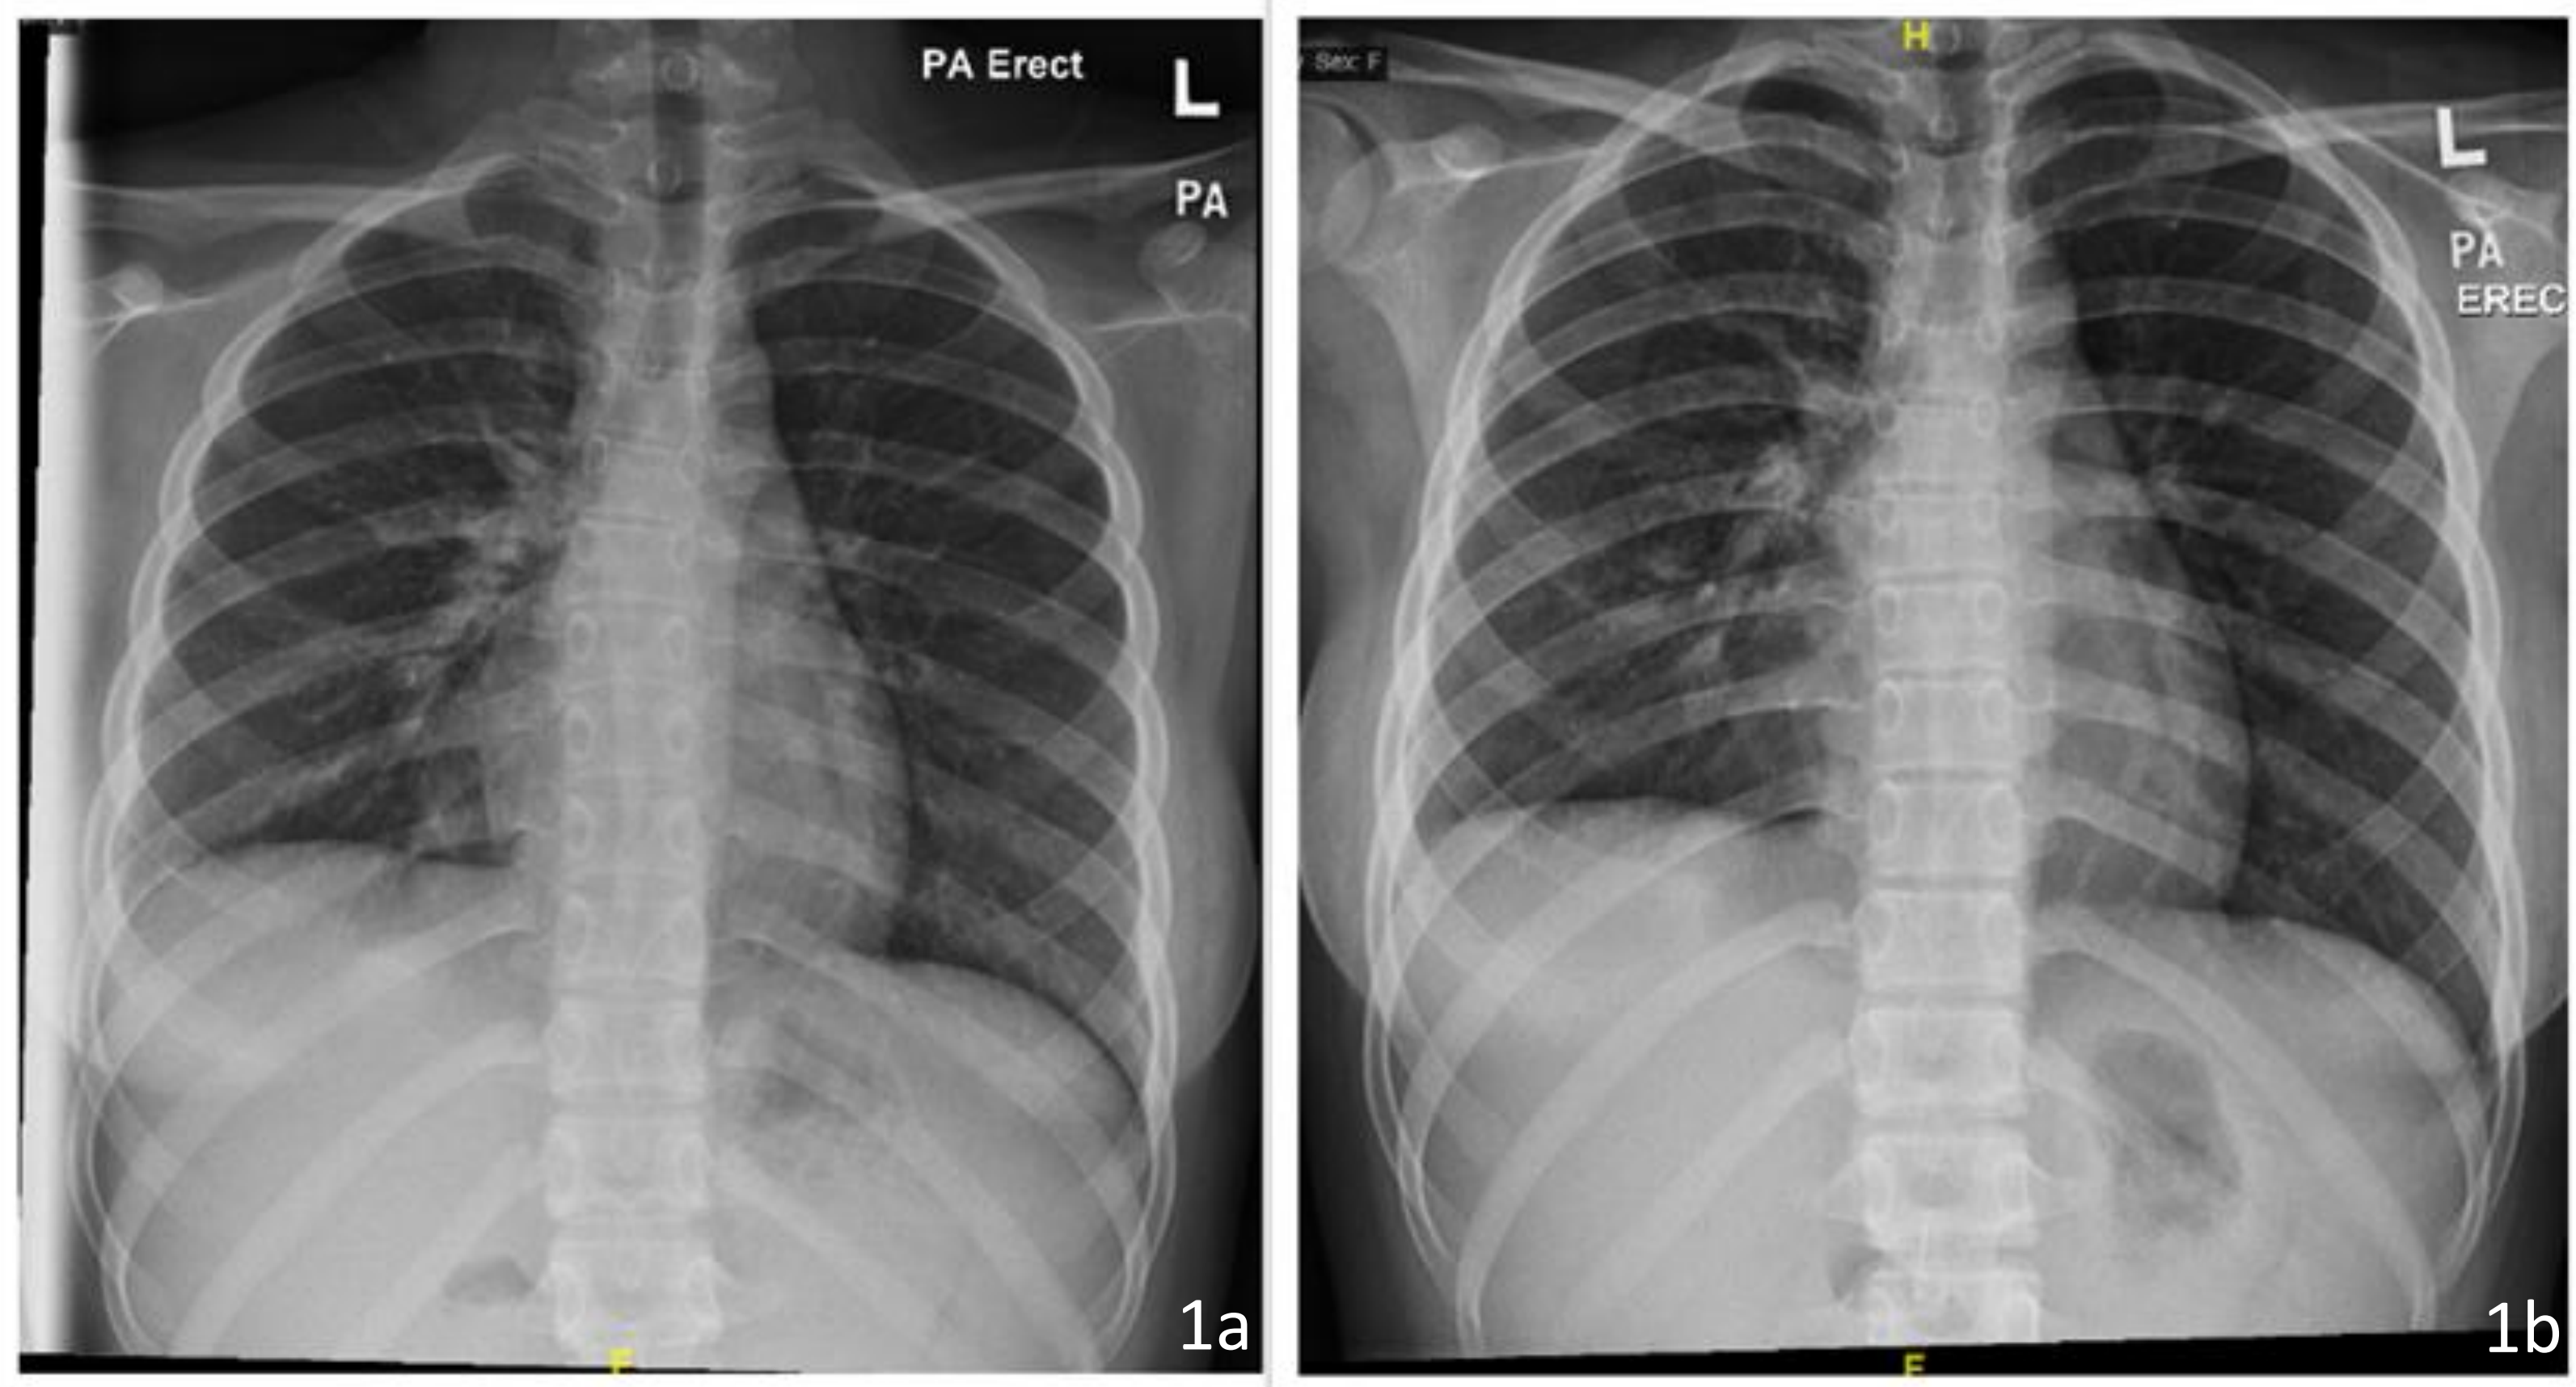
Chest radiographs showing subtle right perihilar haziness at initial presentation (a), with progression over six weeks to right mid and lower zone reticulonodular opacities, right pleural effusion, and elevated right hemidiaphragm (b).
